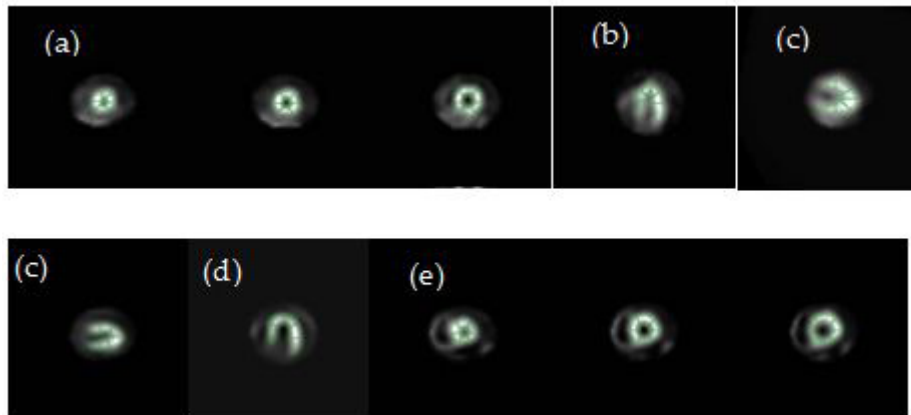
Segmented SPECT studies (stress studies): (a) SA; (b) HLA; (c) VLA and rest studies: (c) SA; (d) HLA; (e) VLA.
